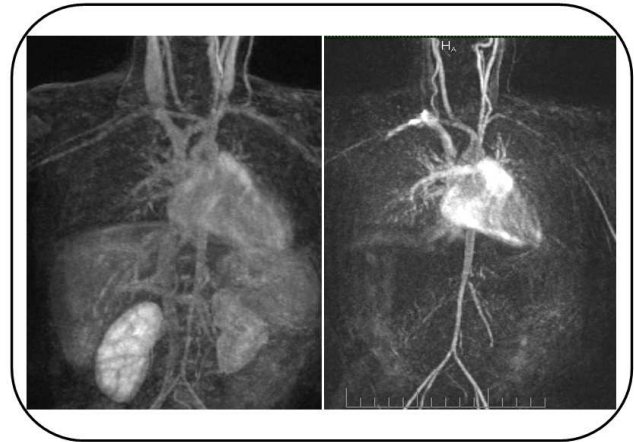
Abdominal MR imaging and Abdominal MRI angiography.
